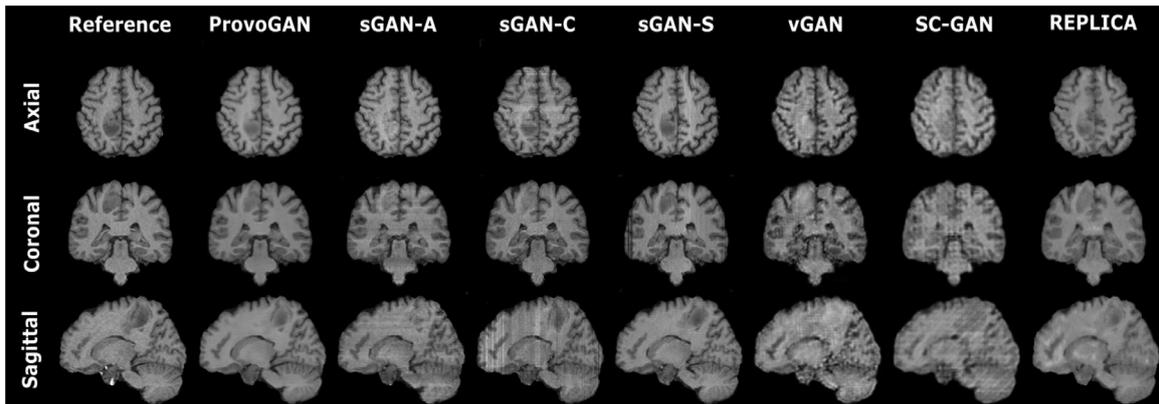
The proposed method is demonstrated on the in vivo brain dataset for T_1 -weighted image synthesis from T_2 -, T_{1c} -weighted and FLAIR images. Representative results are displayed for all competing methods together with the reference target images (first column). The first row displays results for the axial, the second row for the coronal, and the third row for the sagittal orientation. Overall, the proposed method delineates tissues with higher spatial resolution compared to volumetric vGAN, SC-GAN, and REPLICA models, and alleviates discontinuity artifacts by improving synthesis performance in all orientations compared to cross-sectional sGAN-A, sGAN-C, and sGAN-S models. Meanwhile, the proposed method achieves more accurate depictions for tumor regions, which are suboptimally recovered by the competing methods.
